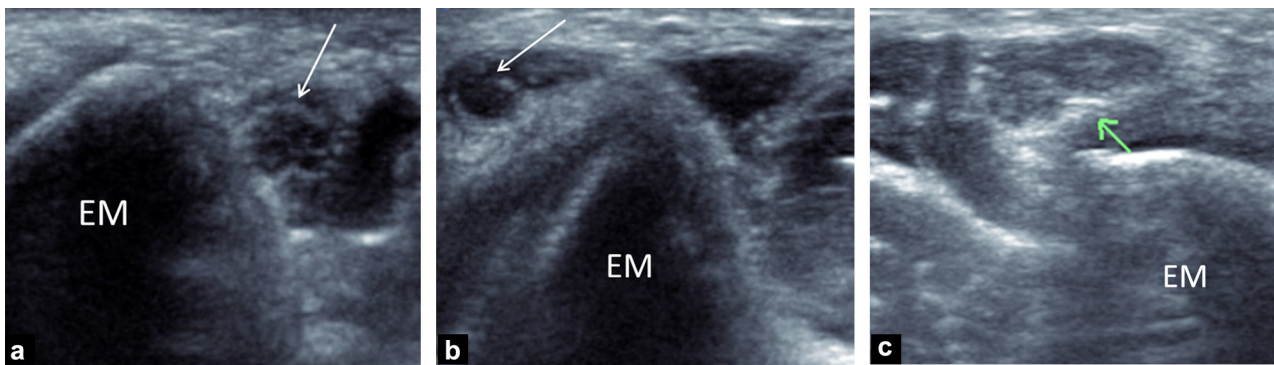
Cases of unstable ulnar nerves (UN) revealed by dynamic ultrasound maneuver. a: case 1, axial view in flexion under 90°: UN (white arrow) in the anatomical position; b: case 1, forced elbow flexion: luxation of the UN in front of to the medial epicondyle. c: case 2: subluxation of the UN (green arrow) during forced elbow flexion, lying above the medial epicondyle (ME), in this case on the left.
